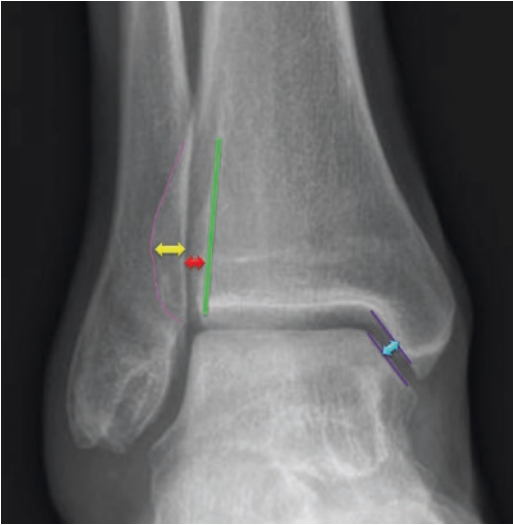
Common radiographic measurements of the ankle. *Medial clear space* (cyan arrow) is measured 5 mm below the level of the talar dome, between the medial aspect of the talus and the lateral aspect of the medial malleolus. *Tibiofibular clear space* (red arrow) is measured 1 cm proximal to tibial plafond, between the medial border of the fibula and the medial shadow of the incisura fibularis (green line). *Tibiofibular overlap* (yellow arrow) is measured 1 cm proximal to the tibial plafond, between the lateral border of the tibia (magenta line) and the medial border of the fibula
